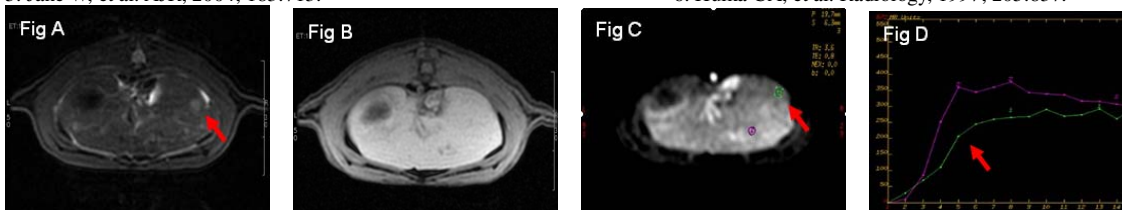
HGDN. The lesion (red arrow) showed mildly hyperintense on fat saturated T2WI (Fig A) and isointense on T1WI (Fig B), DCE-MR images of the DN and adjacent cirrhotic liver (Fig C) and RE-T curves of the DN and adjacent cirrhotic liver (Fig D). The curve of DN (green line) shows a pattern like rapid wash-in followed by a plateau, and the REmax of DN was significantly lower than that of adjacent cirrhotic liver.
